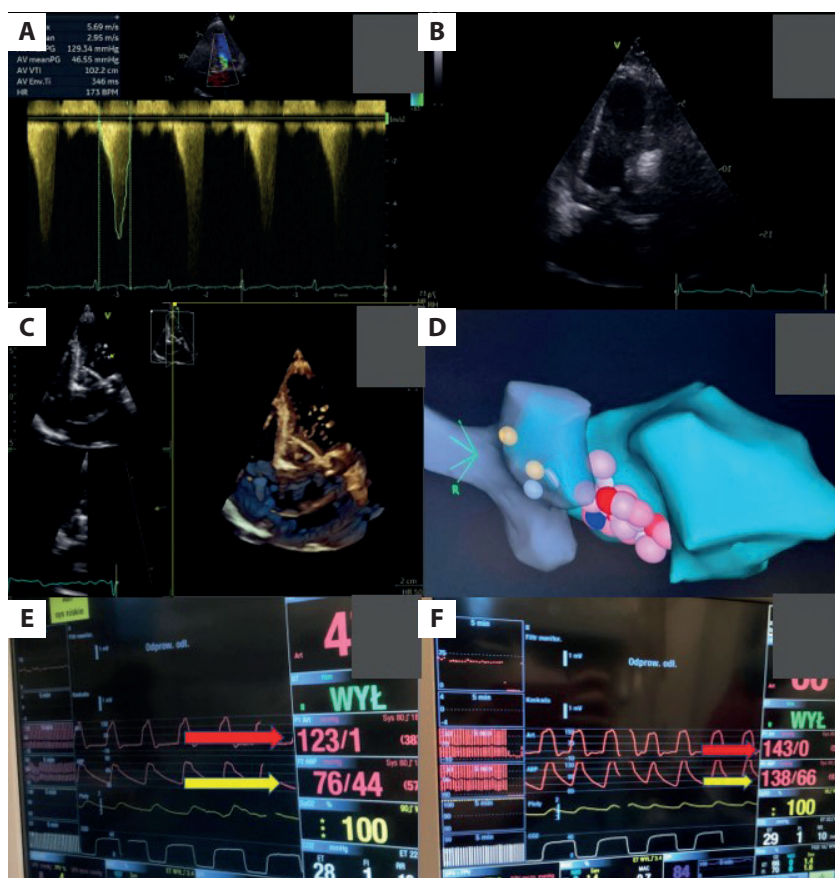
A. Severe obstruction of the left ventricular outflow tract (2D echocardiography, CW Doppler resting gradient). B. Alcohol septal ablation, optimal perfusion of the basal segment of the interventricular septum. C. 3D-echocardiography, position of the ablation catheter. D. 3D-mapping system, area of ablation. E. Hemodynamic measurements at the beginning of the procedure; the red arrow indicates the left ventricular pressure; the yellow arrow indicates the pressure in the ascending aorta. F. Hemodynamic measurements at the end of the procedure; the red arrow indicates the left ventricular pressure; the yellow arrow indicates the pressure in the ascending aorta
